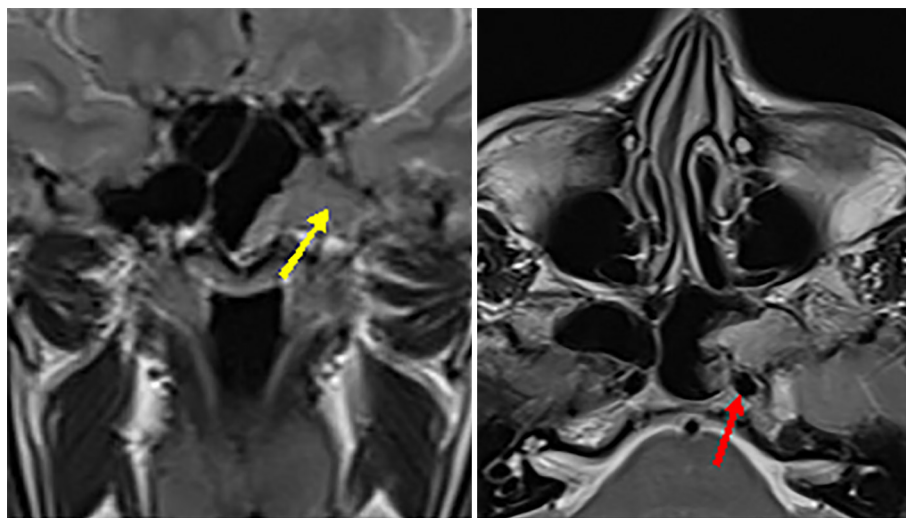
Magnetic resonance imaging (coronal and axial slices) after endonasal biopsy: the inverted papilloma is observed in the left sphenoid sinus with extension into the lateral recess (yellow arrow), the protruding internal carotid arteries within the sphenoid sinus, and the left carotid artery in contact with the tumor (red arrow)..
